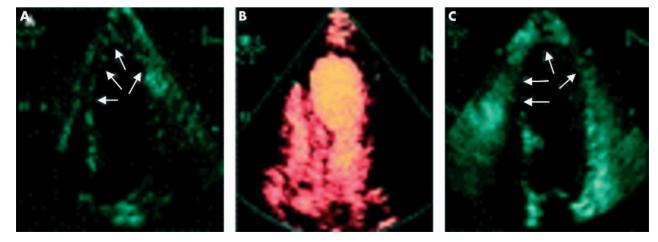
(A) Apical four chamber view in systole showing akinetic mid septum and apex (arrows) 12 hours after successful PTCA. (B) No contrast opacification seen in mid septum and apex. (C) Follow up echocardiography at one month, showing lack of recovery of function of these segments (arrows) with no change in left ventricular end systolic volume.
